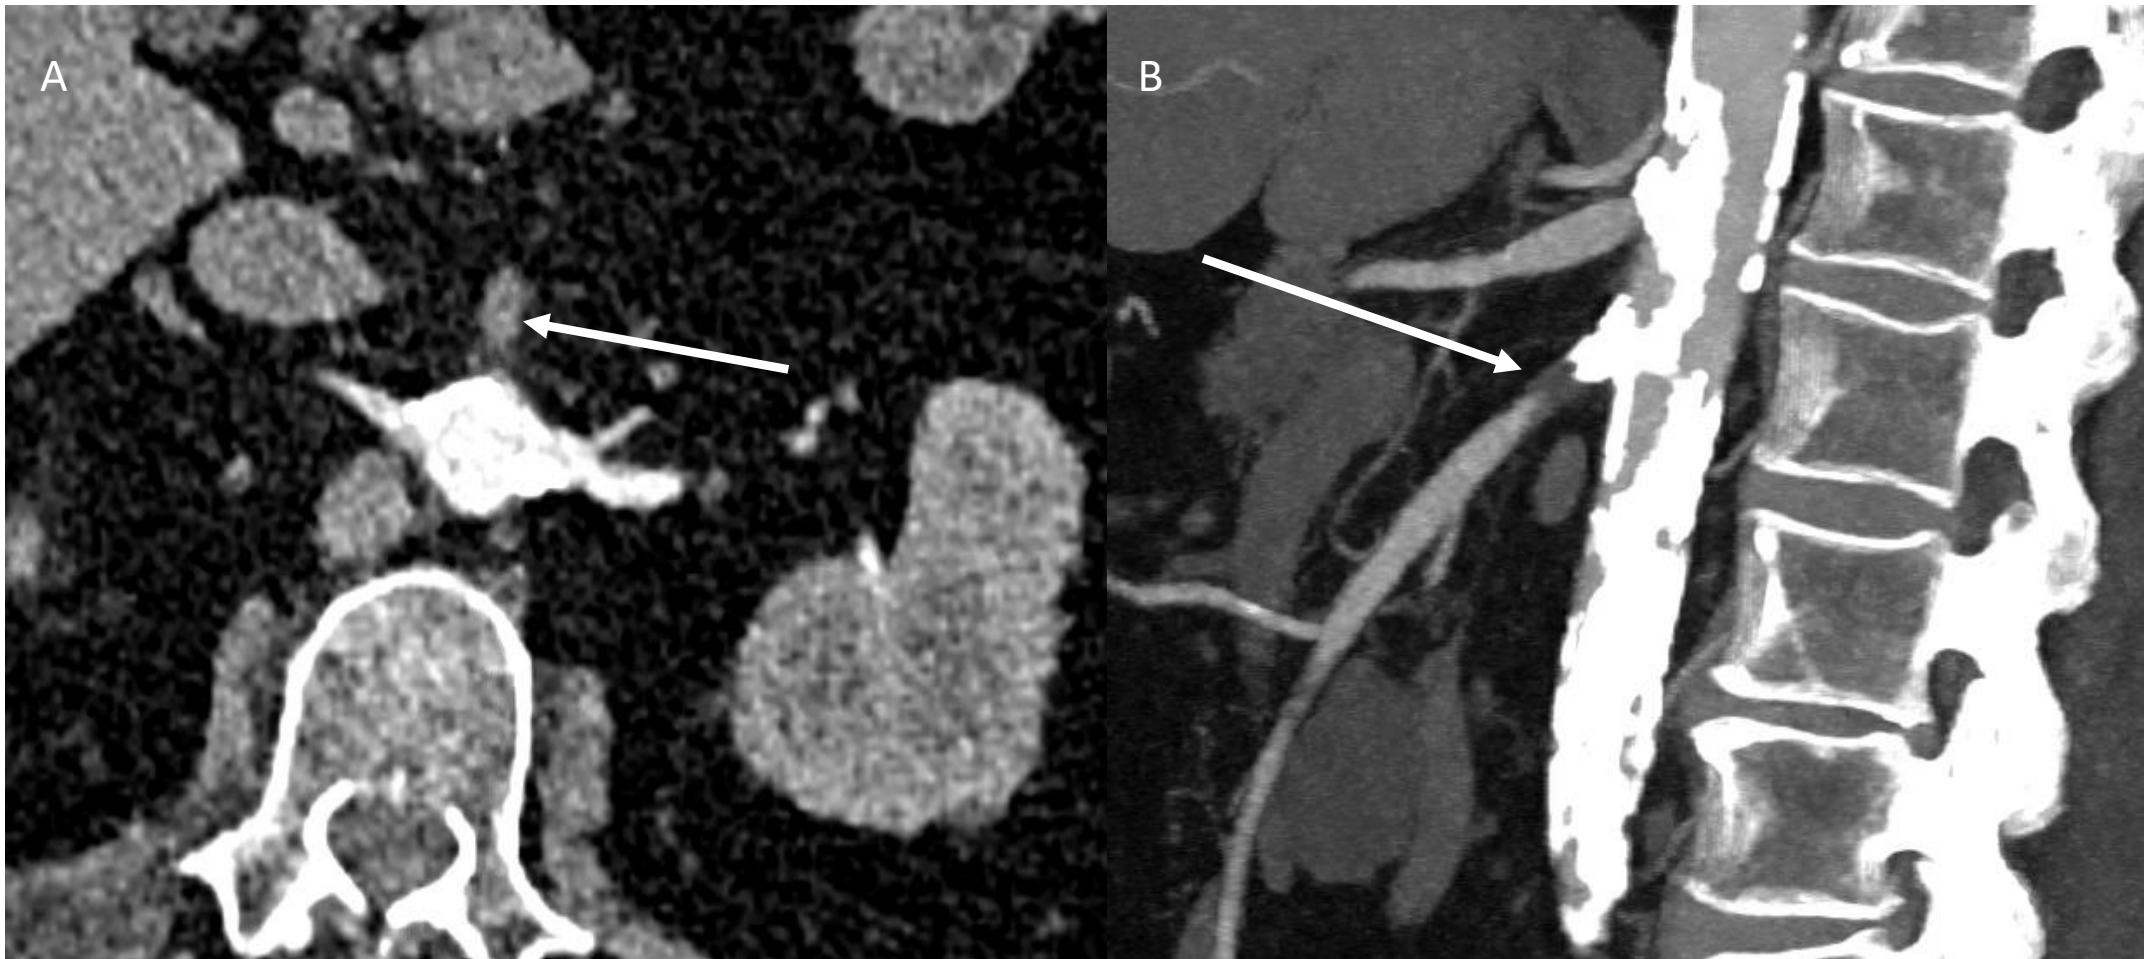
Abdominal CT-scan of a 77 years old patient with AMI showing an incomplete occlusion of the S2 segment of the SMA (arrow) : (A) axial view and (B) sagittal view
